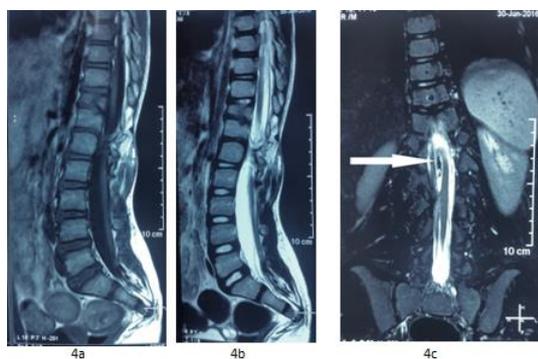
MRI spine. (a) T1W sagittal section shows vertebral anomaly at D11 level with associated inhomogeneous intensity of the cord. (b) T2W image shows the same findings with dural sac abnormalities and spur delineation. (c) T2W coronal section shows hypo intense region of osseous spur.
